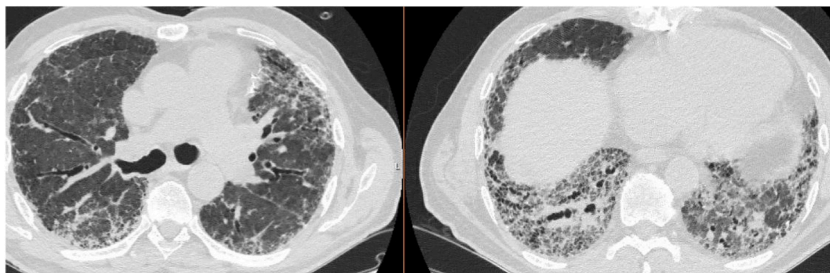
Patient CT Chest.
